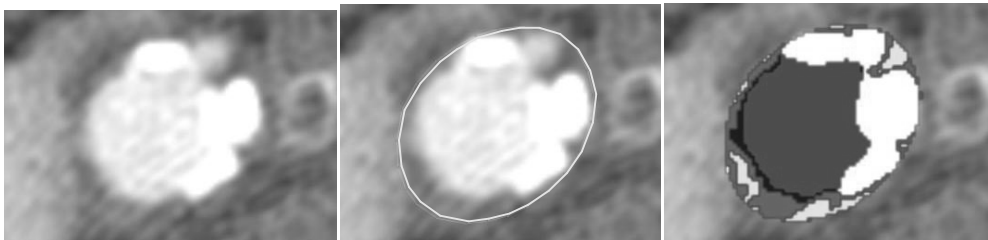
Example of a carotid artery CTA scan axial view (left), with contour drawn by a trained observer (center) and with different tissue shown in different colors (right): red – lumen, blue – non-calcified tissue with Hounsfield values (HV) ranging from 130 HU till luminal HU, green – fibrous tissue with HV ranging from 60-130 HU, yellow – lipid with HV ranging from 0-60 HU, white – calcium with HV above 130 HU.
